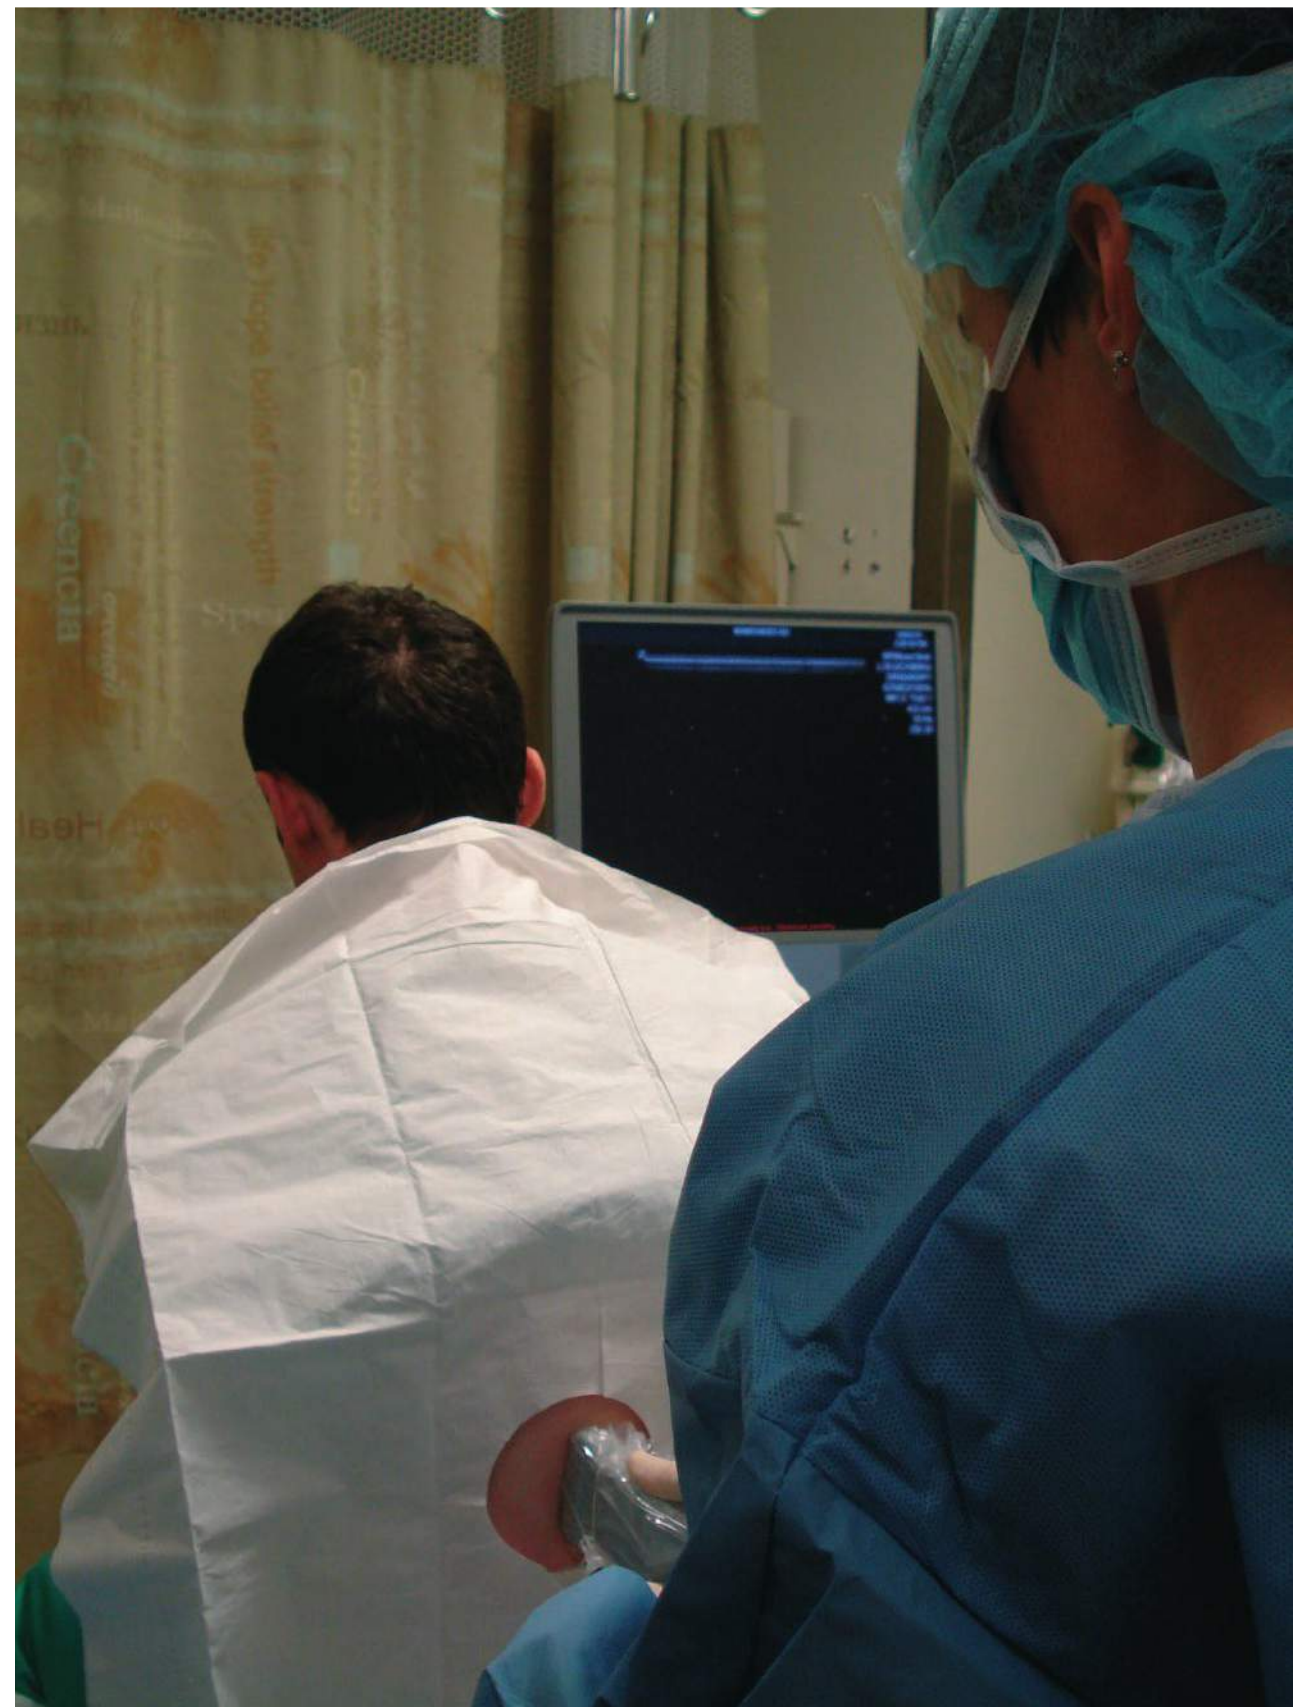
Note the relationship between patient and ultrasound machine.
